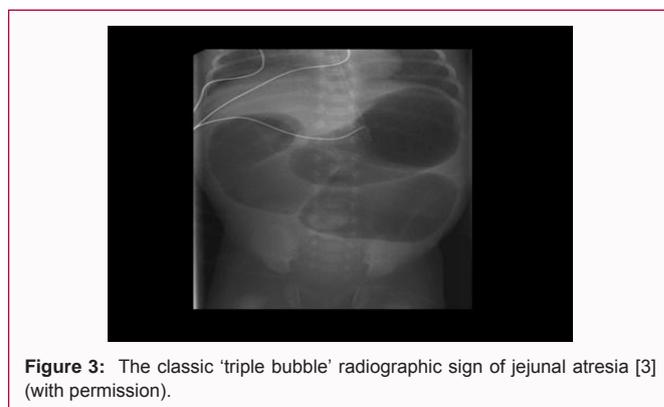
The classic 'triple bubble' radiographic sign of jejunal atresia [3] (with permission).
